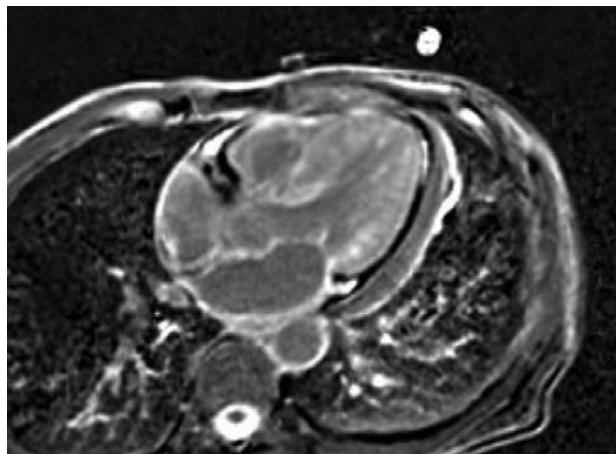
Cardiac MRI showing moderate sized pericardial effusion and concentric left ventricle wall hypertrophy in a patient with cardiac amyloidosis.
